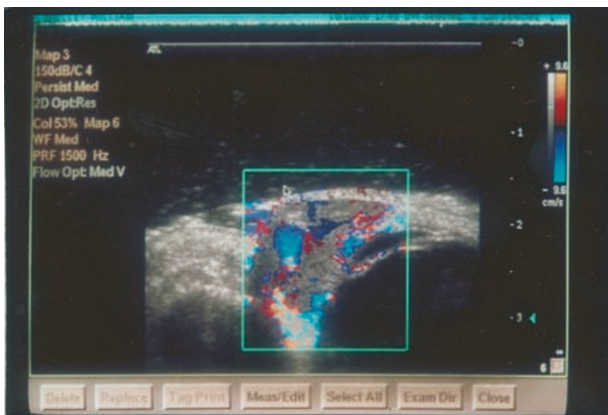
Colour Doppler picture of the same lesion. Multiple vascular channels showing moderate to high flow (blue and red). The pulse repetition frequency (PRF) has been set at 1500 Hz to maximise detection of vessels. The resultant aliasing artefact can be avoided by reducing the PFR.
